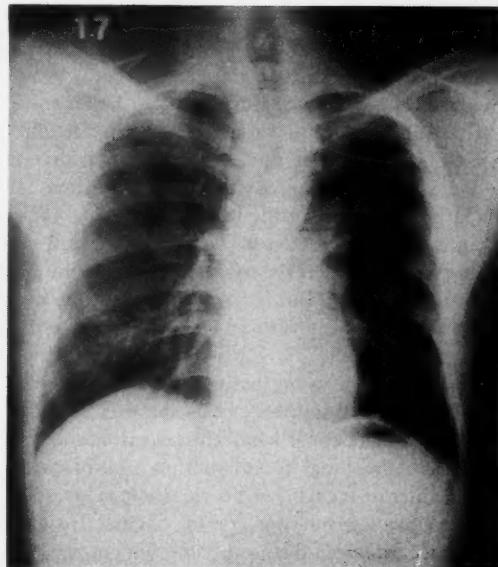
X-ray of same patient as in Fig. 3 at 18 months of chemotherapy.
